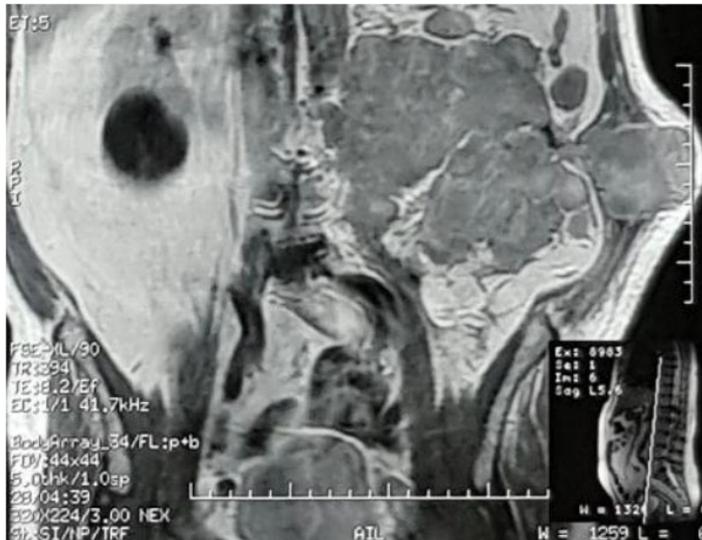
The magnetic resonance imaging shows the recurrent mass infiltrating the abdominal wall and the adjacent structures.
